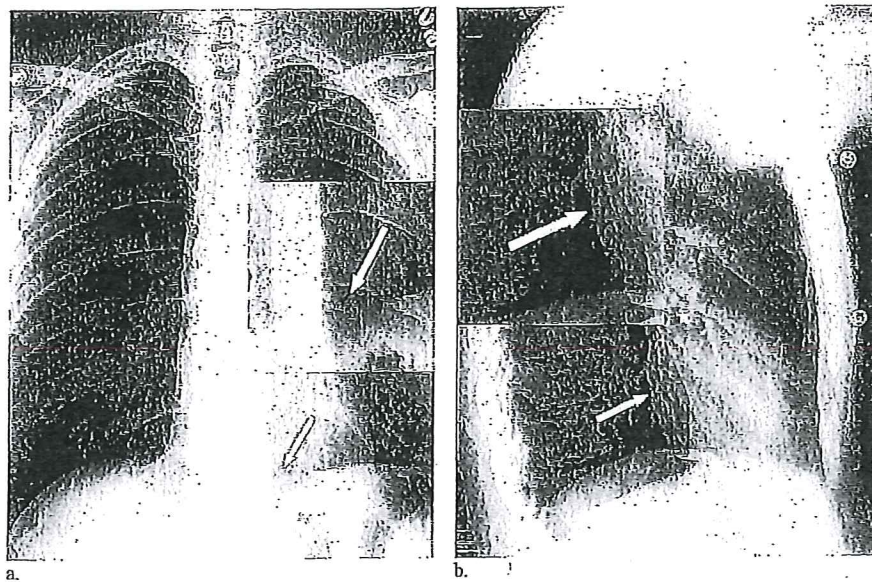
Posteroanterior (a) and lateral (b) chest radiographs demonstrate an embolized short limb (arrows) projecting over the right ventricle. Insets show a magnified view of the fracture fragment.
